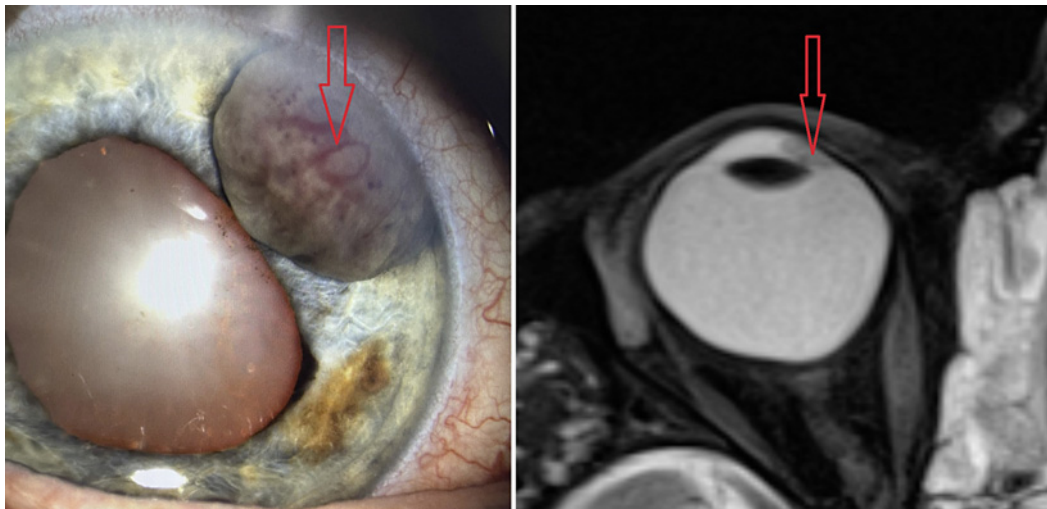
Left: clinical status before stereotactic irradiation and block excision surgery – the anterior segment of the eye (red arrow – the tumor). Right: MRI finding of the eye with the tumor on the anterior segment before stereotactic surgery (red arrow – the tumor).
